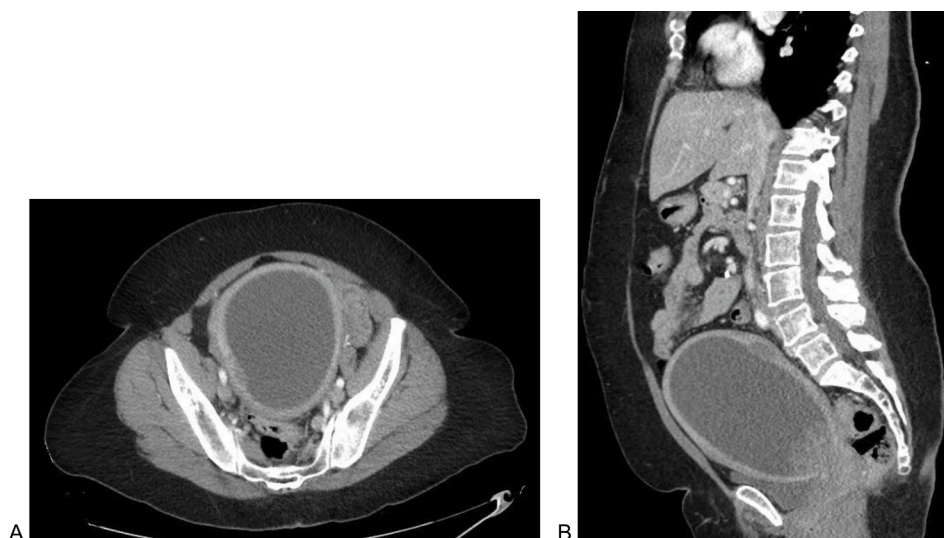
CT imaging axial [A] and sagittal [B] views of the uterus demonstrating an enlarged uterus with complex mass with cystic and solid component measuring 15 × 8.5 × 9.8 cm.
